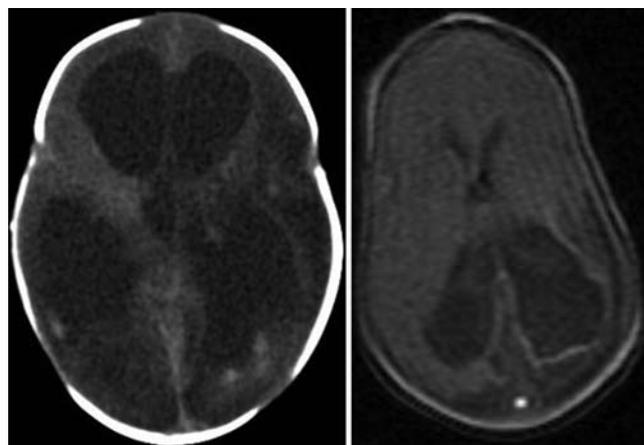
Computed tomography scan obtained before (left) and MR image after (right) reservoir tapping in the patient in Fig. 1. In this case reservoir tapping alone was sufficient to halt the progression of hydrocephalus.
